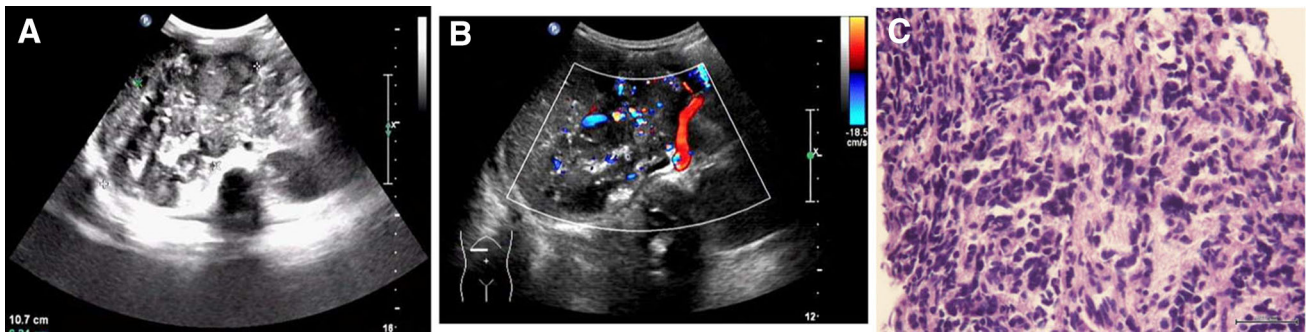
Ultrasound examination and biopsy of a patient (female, 3 years old) with neuroblastoma. a, b It showed the solid tumor in the retroperitoneal, with inhomogenous echo, calcification, and rich blood flow signal in the tumor. c Biopsy suggested that it was a right retroperitoneal neuroblastoma (amplification $\times 400$)
